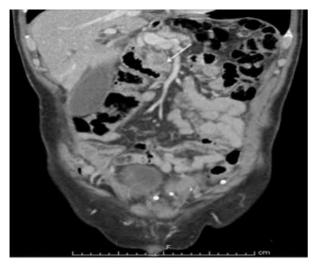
Abdominal CT scan showing a low-attenuation mass (arrow) in the head of the pancreas and uncinate process, consistent with pancreatic adenocarcinoma.
